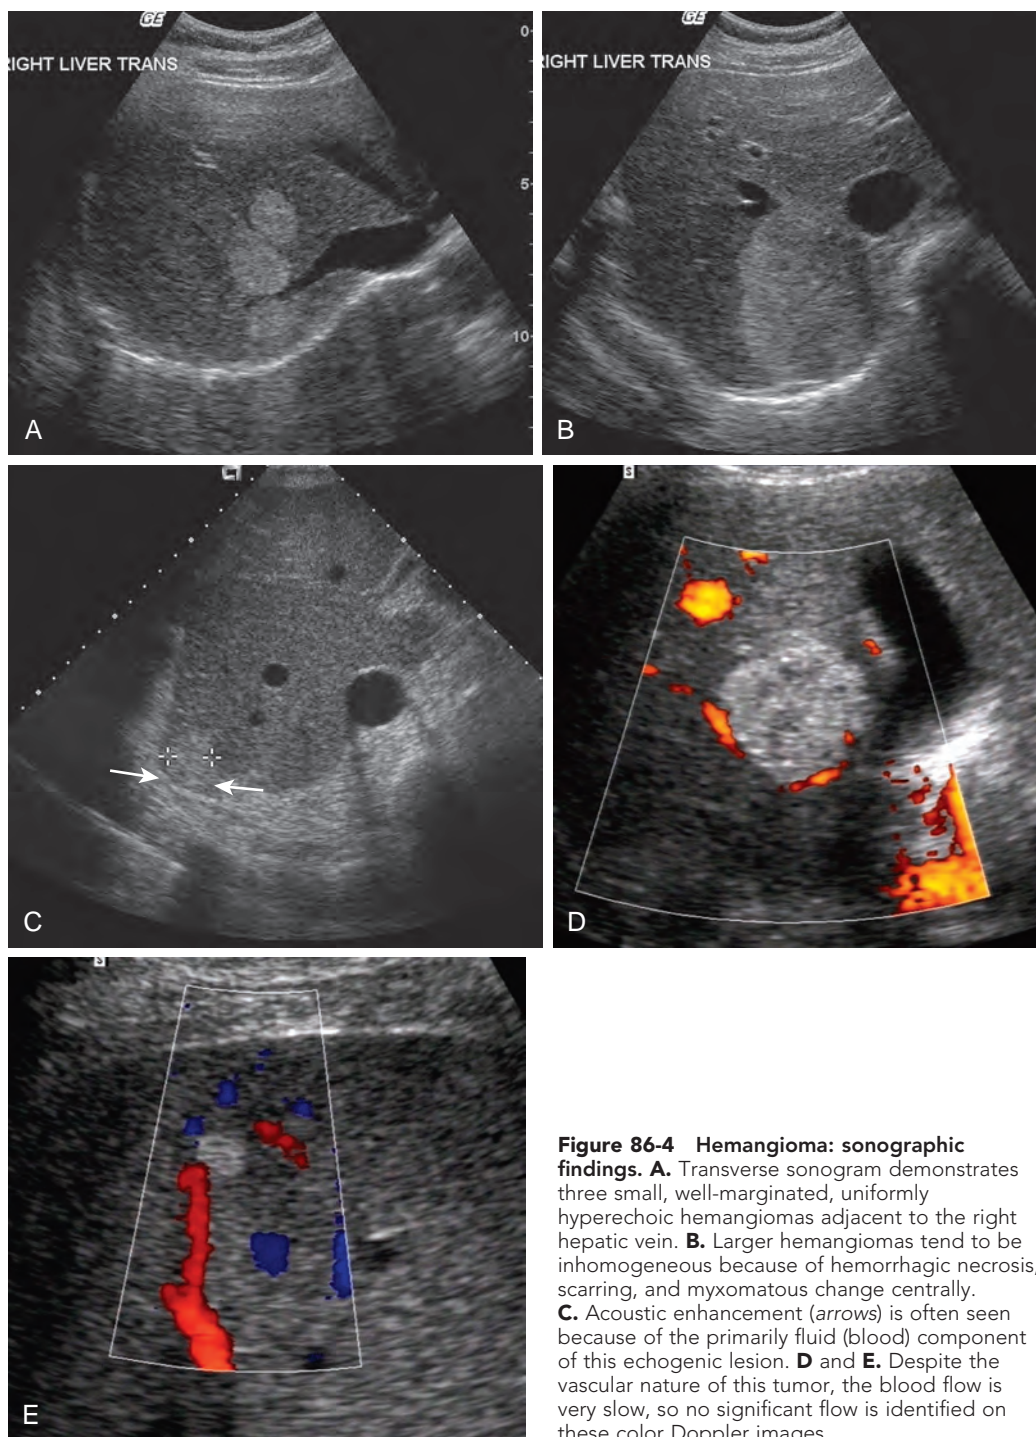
Hemangioma: sonographic findings. A. Transverse sonogram demonstrates three small, well-margined, uniformly hyperechoic hemangiomas adjacent to the right hepatic vein. B. Larger hemangiomas tend to be inhomogeneous because of hemorrhagic necrosis, scarring, and myxomatous change centrally. C. Acoustic enhancement (arrows) is often seen because of the primarily fluid (blood) component of this echogenic lesion. D and E. Despite the vascular nature of this tumor, the blood flow is very slow, so no significant flow is identified on these color Doppler images.
